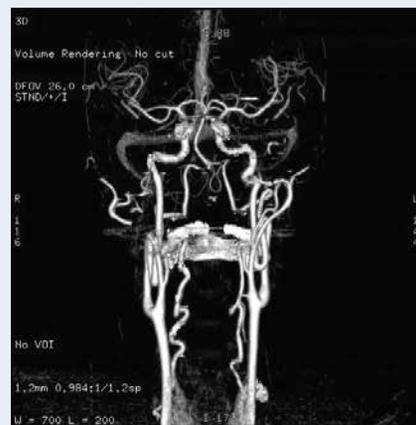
Computed tomography angiography excluded dissection of tight kinking of both internal carotid arteries and tortuous vertebral arteries
